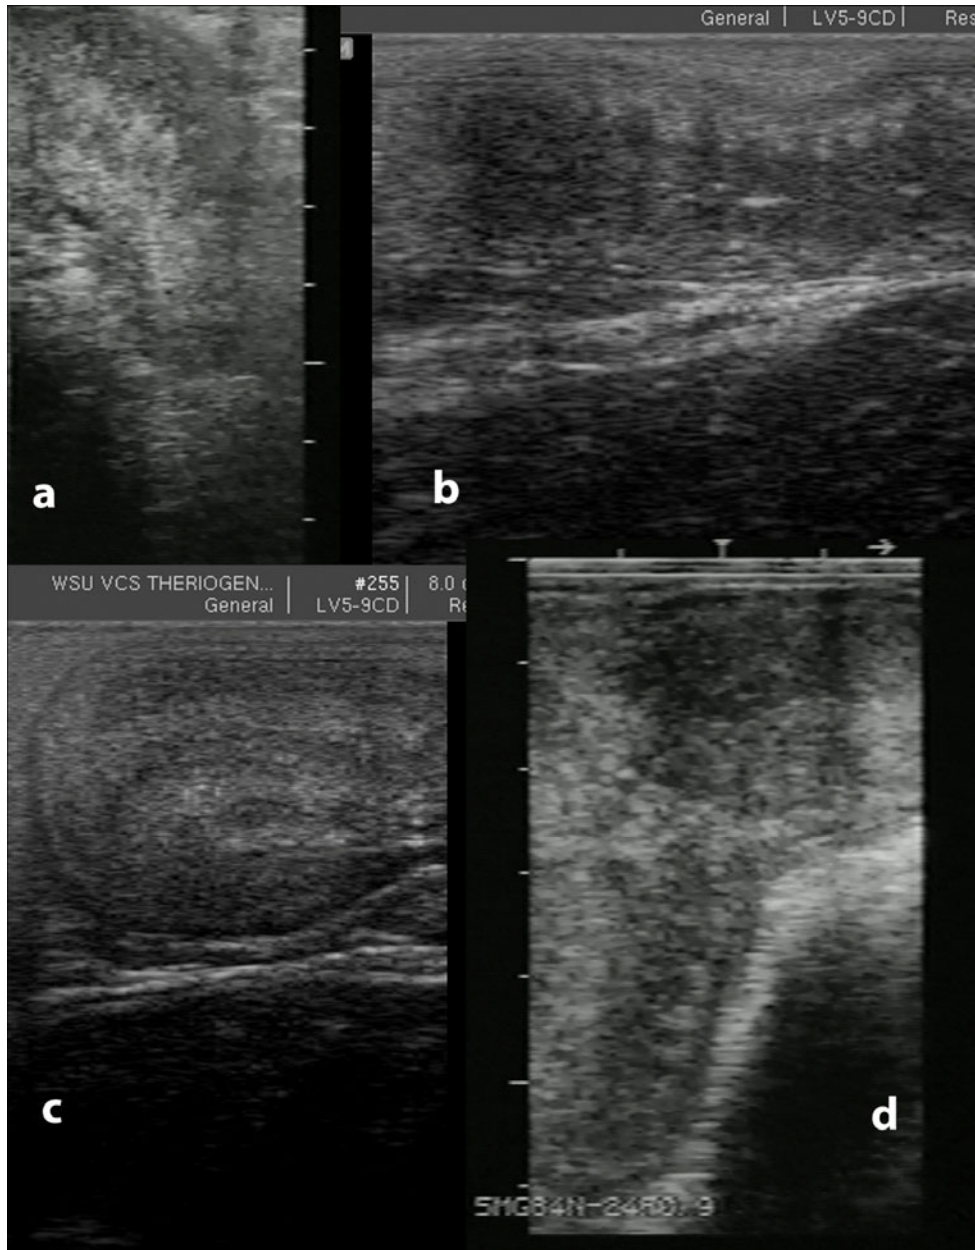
Ultrasonograms of the uterus during different stages of follicular development and after ovulation. a-b) Increased edema and tone (follicular phase), c-d) Relaxed and homogenous (luteal phase).
